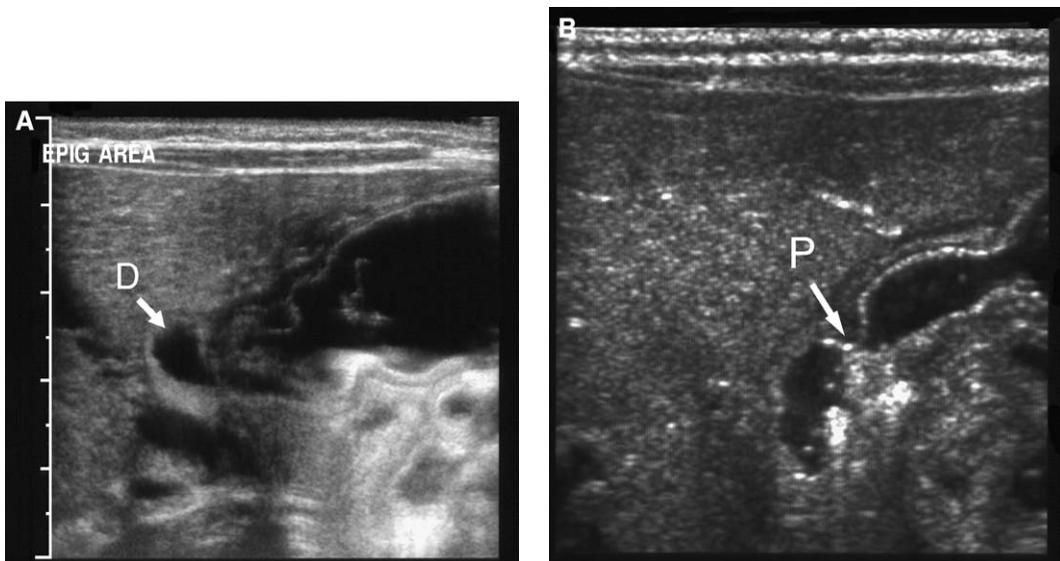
(A, B) Sonographic images of the pylorus after the infant was given a small amount of fluid. Both images show fluid within the antrum passing through a normal pylorus (P, arrow) into the duodenum (D, arrow).
